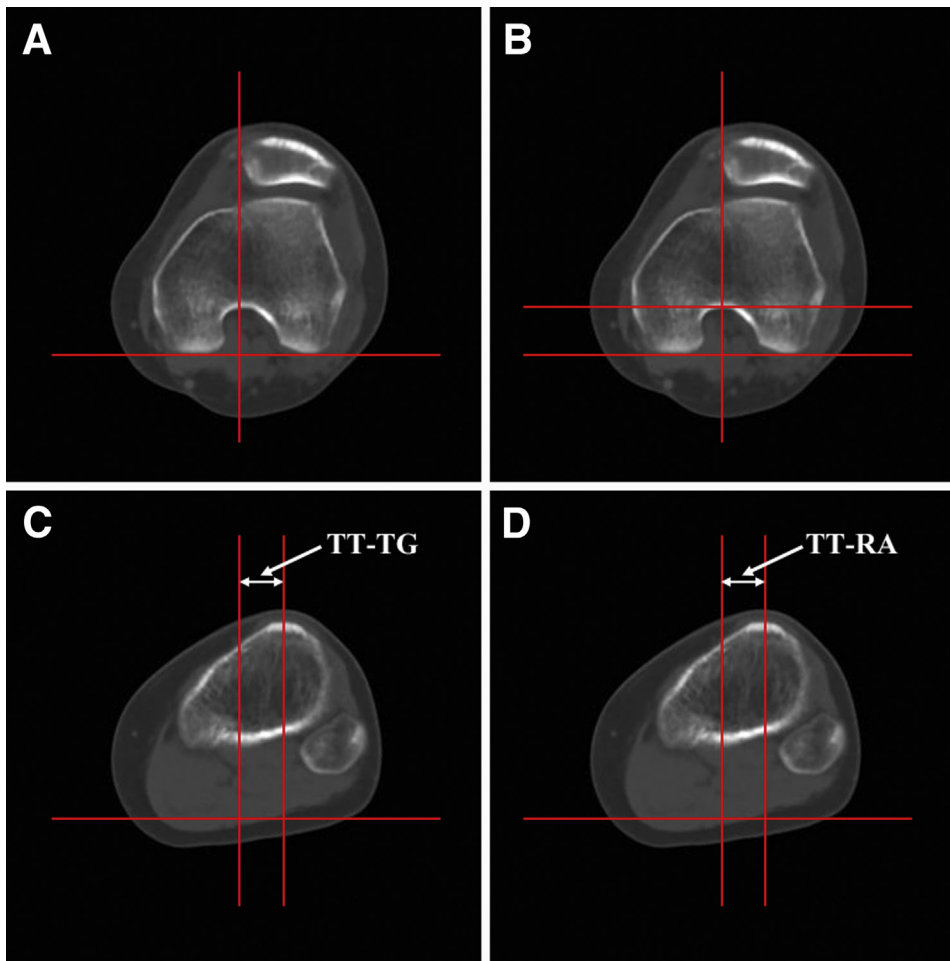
The measurements of tibial tubercle-trochlear groove (TT-TG) distance and tibial tubercle-Roman arch (TT-RA) distance. (A) The CT slice for the evaluation of the trochlear groove and posterior condyles. (B) The CT slice for the evaluation of the highest point of Roman arch and posterior condyles. (C) and (D) The center of tibial tubercle. TT-TG distance (the overlapping image of A and C): the distance between the trochlear groove and the center of tibial tubercle. TT-RA distance (the overlapping image of B and D): the distance between the highest point of Roman arch and the center of tibial tubercle.
